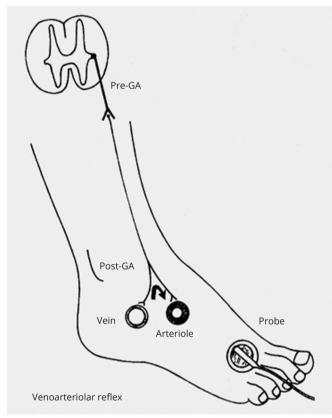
The venoarteriolar reflex. Pathway of the VAR. The probe of the laser Doppler used to detect the VAR is placed at the distal part of the foot
